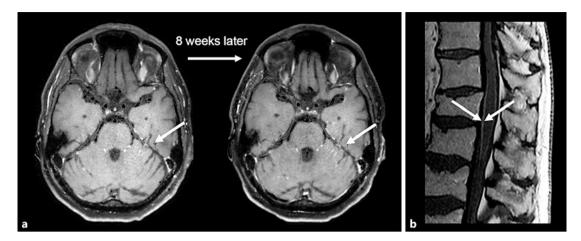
a Contrast-enhanced cerebral MRI at baseline (left) with nodular and linear contrast enhancement in the cerebellum, consistent with leptomeningeal carcinomatosis. Follow-up MRI (right-hand side) shows a slight increase in contrast enhancement. b Contrast-enhanced spinal T1-weighted MRI of the spine (right) with leptomeningeal contrast enhancement.
